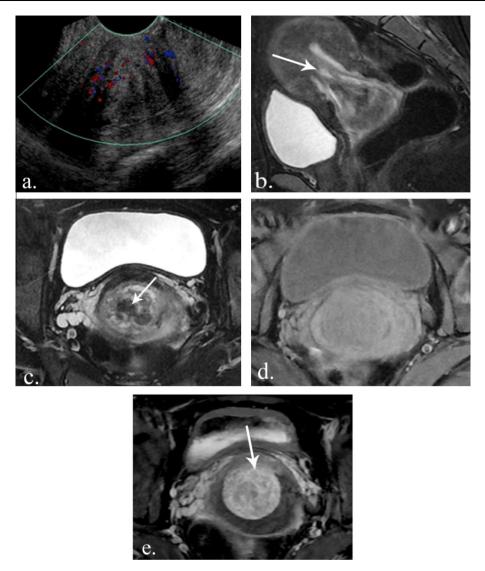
Pedunculated submucosal fibroid with prolapse and torsion. The patient presented to the emergency department with acute pelvic pain and vaginal bleeding. (a) Transvaginal ultrasound revealed a mass lesion that is seen filling and expanding the cervical canal and protruding into the upper vagina, was interpreted as cervical polyp. (b) Sagittal T2 fat sat. image demonstrates a fibroid arising on a stalk (white arrow) that originates in the lower endometrial cavity. (c) Axial T2 image demonstrates the fibroid has prolapsed into the endocervical canal and demonstrates areas of low signal at T2 (black arrow) suggestive of hemorrhage. (d) Axial T1 fat saturated image demonstrates high signal intensity within the fibroid indicating hemorrhage. Axial T1 fat-saturated image following gadolinium administration demonstrates inhomogeneous enhancement with areas of low signal intensity consistent with torsion (white arrow).
